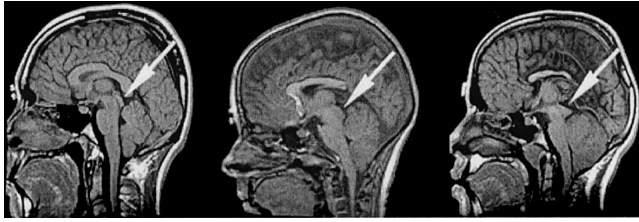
Tectal beaking in midsagittal structural MRI slices for a control participant with normal tectum (left), a spina bifida meningocele (SBM) participant with normal tectum (middle), and an SBM participant with beaked tectum (right). Arrows point to the midbrain-tectal area.
